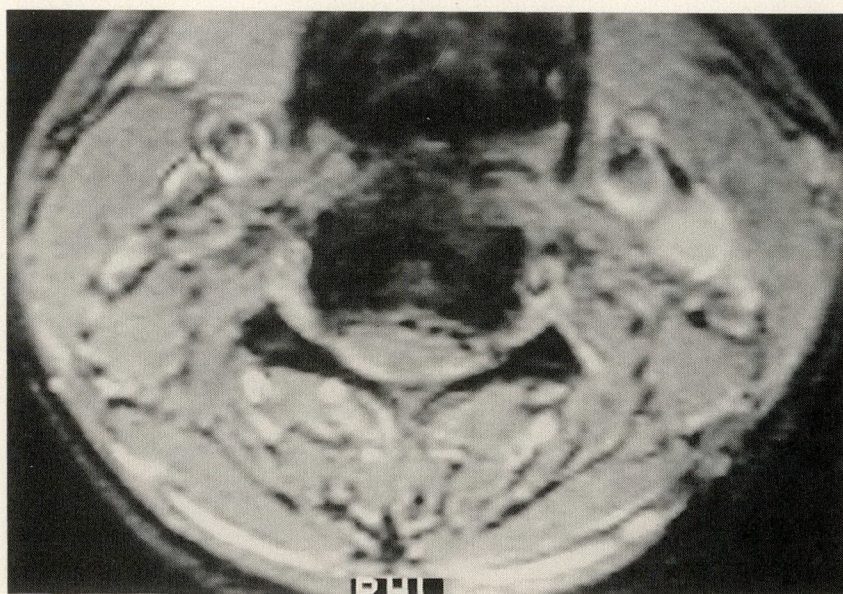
Axial magnetic resonance image shows loss of cerebrospinal fluid anterior to spinal cord and cord compression.
